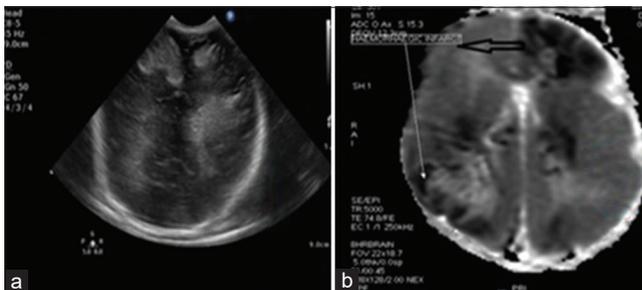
Ultrasound brain (a) and computed tomography brain (b) showing intraventricular and intraparenchymal bleed.
